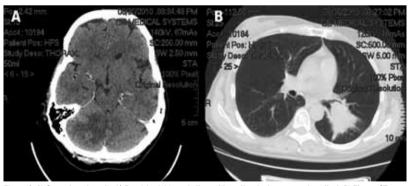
A) Secondary deposits (1.5 cm) in right cerebellum with perifocal edema were described; B) Thorax CT scan showed a tumor-like change in the left lung hilum, which deformed left main and lower bronchi
